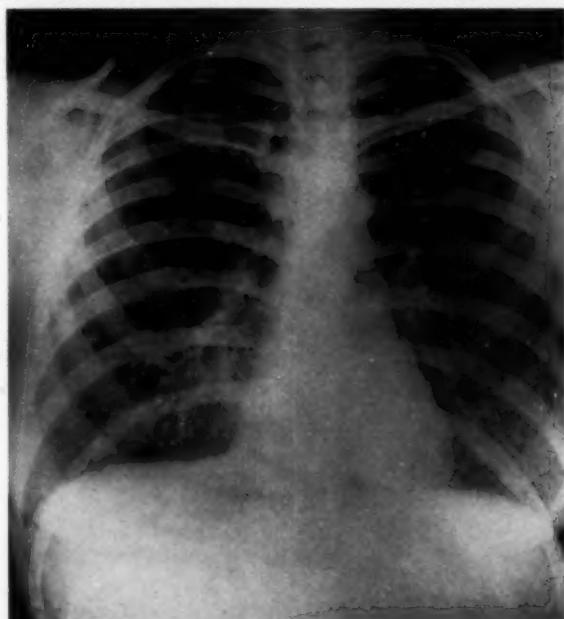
Case 2, Initial chest roentgenogram July 3, 1959, showing diffuse infiltrations of small patchy and streaky areas throughout both lung fields.
